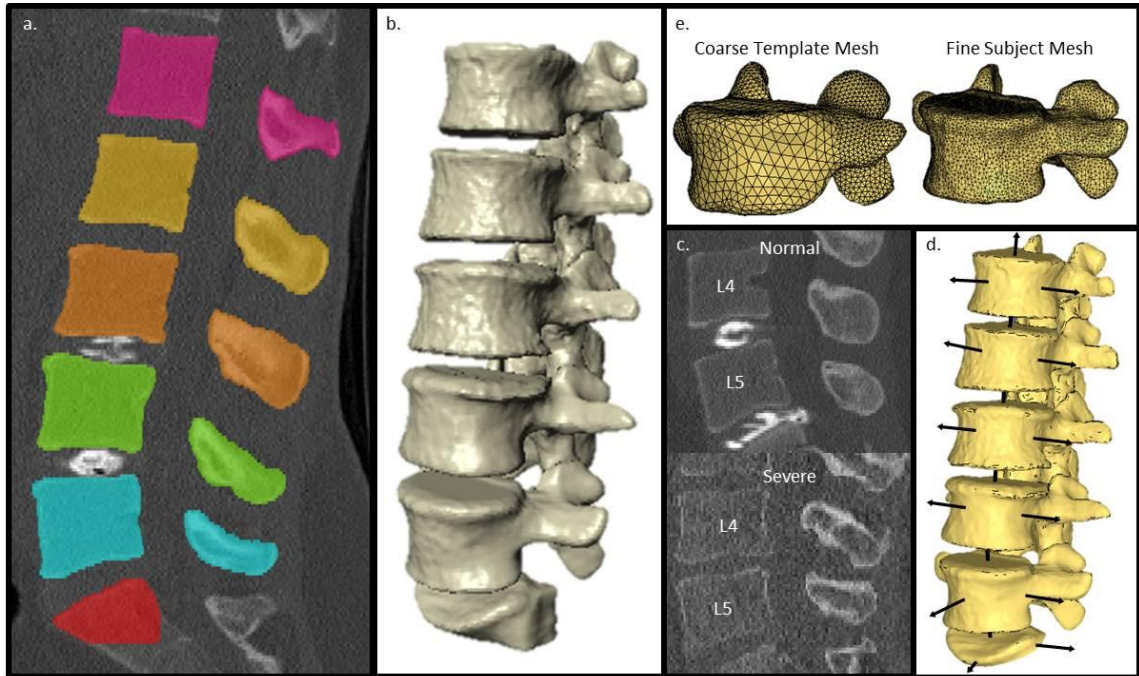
a) Geometries segmented from computed tomography images, b) 3D model of patient geometry, c) Healthy normal and severe degeneration cases, d) local anatomic coordinate system developed for each vertebra, e) mesh densities for template and subject meshes.
